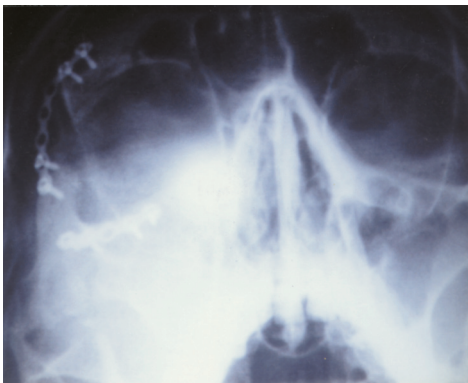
Post-operative plain X-ray after fixation by mini plates and screws.
